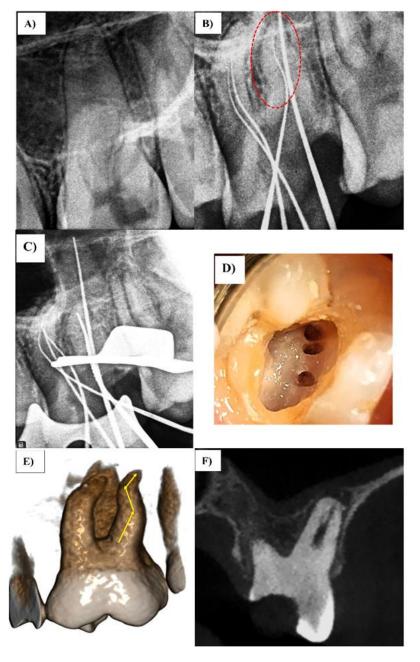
A) Pre-operative radiograph, B) Intraoperative radiograph showing calcified canals along the mesiobuccal root and S- shaped curvature along distobuccal root, C) Radiograph showing working length determination, D) Clinical photograph of tooth 26 showing 3 mesiobuccal canals, E) CBCT image of tooth 26 showing curvatures along mesiobuccal and distobuccal roots, F) CBCT Sagittal section showing ledge created along the distobuccal root while rotary instrumentation.
